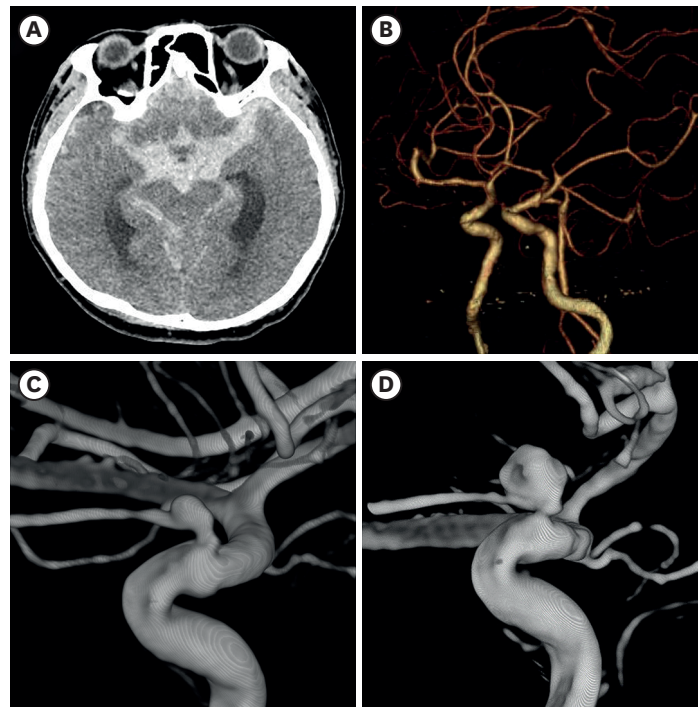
(A) Plain computed tomography scan which shows dense subarachnoid hemorrhage along basal cistern. (B) Initial CT angiography which shows no evidence of aneurysm or dissection. (C) Digital subtraction angiography reveals dissecting aneurysm originating from proximal ophthalmic artery. (D) 5 mm size increased aneurysm on hospital day 14.
